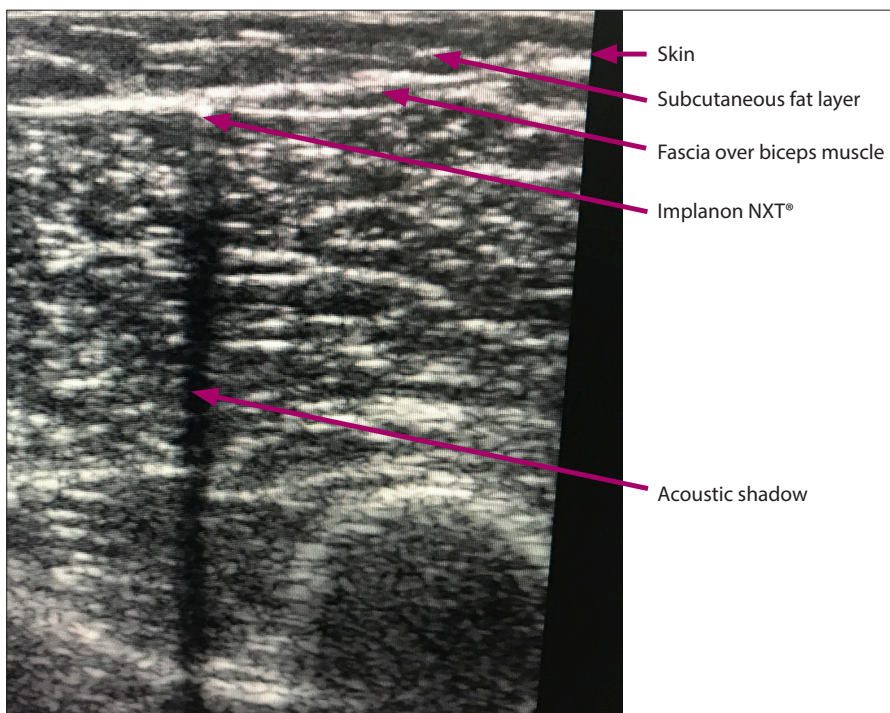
Ultrasound image. The implant is the white dot beneath fascia. Long acoustic shadow is demonstrated.
